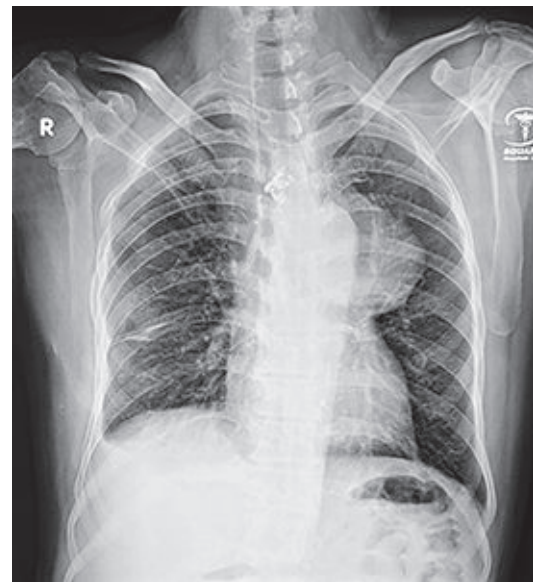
Post-operative X-ray showing remaining aneurysmal sac just before discharge
